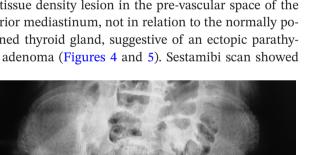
Radiograph of the pelvis with both hips showed osteopenia with a coarse trabecular pattern. Widening and irregularity of both femoral epiphyseal plates were noted. There was an inferior displacement of both femoral heads with respect to the metaphysis.
